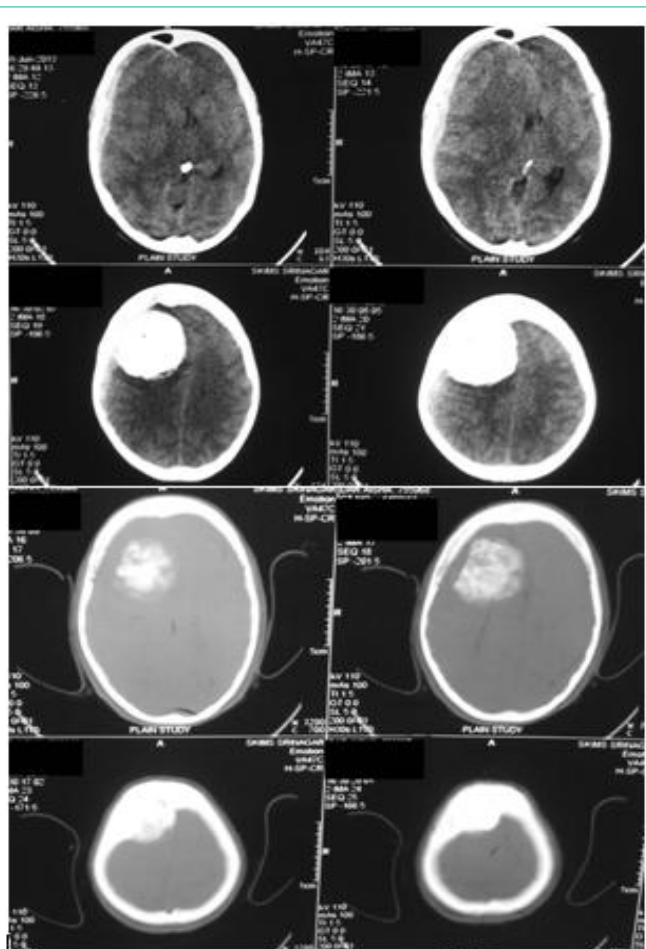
CT scan head showing right frontal convexity meningioma with acute subdural hematoma and midline shift.
